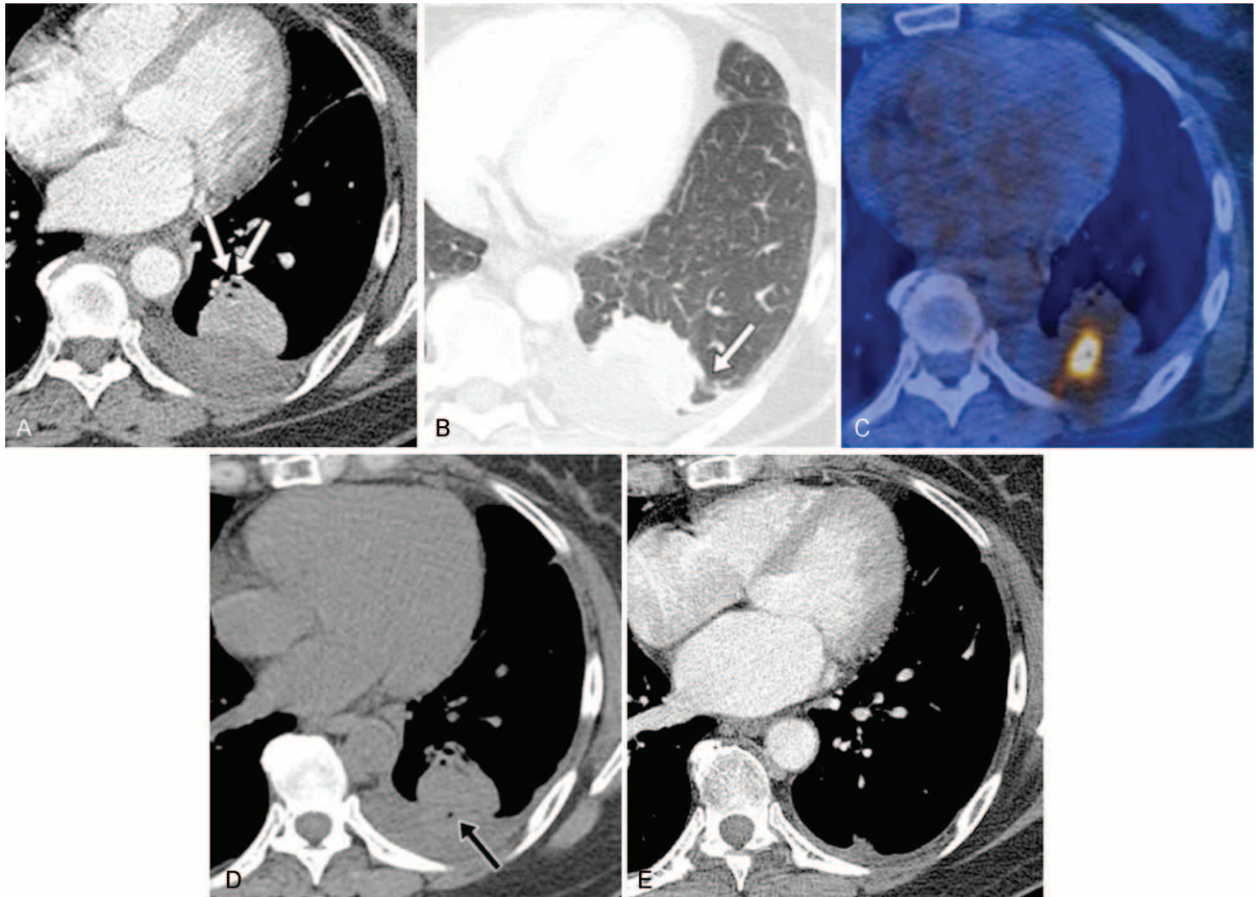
A 53-year-old woman with left pleuritic chest pain and a left lower lobe mass. A, Mediastinal window image of contrast-enhanced computed tomography (CT) shows a 5.5 cm-sized well-defined pleural-based mass appearing as a homogenous enhancement in the left lower lobe, with accompanying pleural effusion. Converging bronchovascular markings, referred to as the “comet-tail” sign, are noted at the proximal aspect of the mass (arrows). B, On the lung window image of CT, subsegmental atelectasis is noted toward the mass (arrow). C, Positron emission tomography/computed tomography scan reveals abnormally increased fluorodeoxyglucose uptake not only within the mass [standardized uptake value (max)=9.3], but also in the left pleura and pleural effusion [standardized uptake value (max)=2.7]. D, Noncontrast CT scan obtained during the Positron emission tomography/computed tomography scan shows air bubbles at the hypermetabolic area (arrow), suggesting fluorodeoxyglucose uptake along the biopsy tract. E, On the mediastinal window image of contrast-enhanced chest CT performed 1 month later, the previously noted mass and pleural effusion had spontaneously resolved without treatment.
